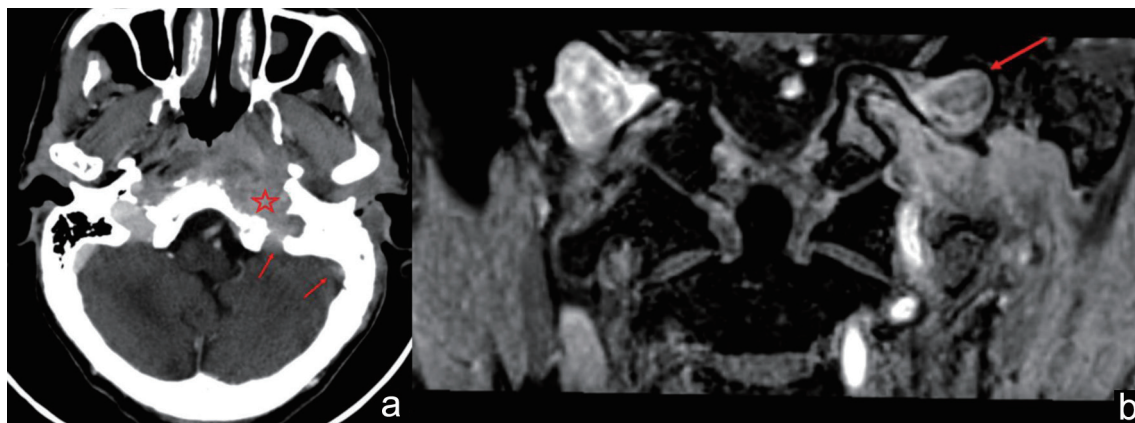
(a) Computed tomography (CT) scan after the administration of contrast medium shows thrombosis of the sigmoid sinus and jugular bulb (red arrows), which is inseparable from the pathological tissue (red star). (b) Magnetic resonance imaging (MRI) coronal T1w image after gadolinium administration. Thrombosis of jugular bulb (red arrow).
